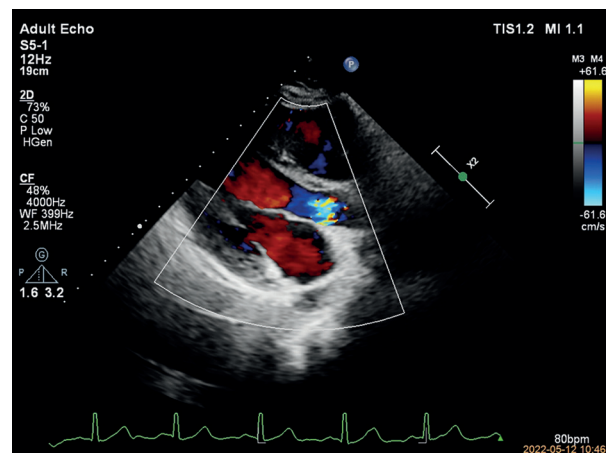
Transthoracic echocardiography, left ventricular long axis. Follow-up observation; no aorta and the left atrium shunt
